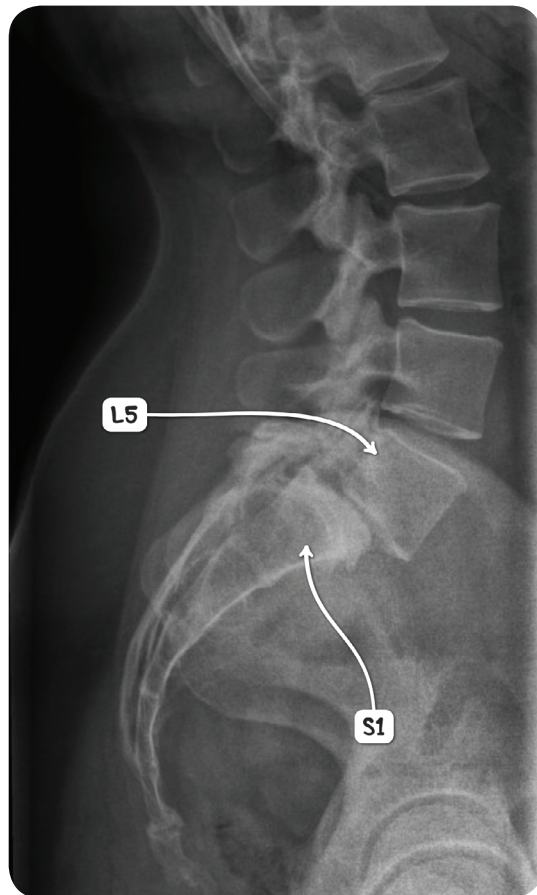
A lateral X-ray image of the spine demonstrating spondylolisthesis at L5/S1.
